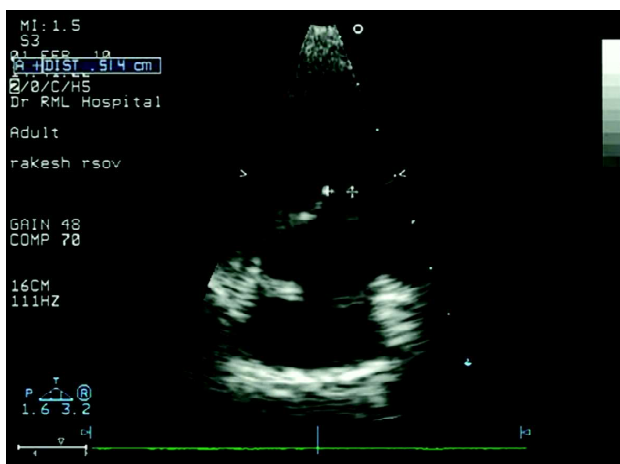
Parasternal short axis view showing the defect (marked between two "v" signs).
